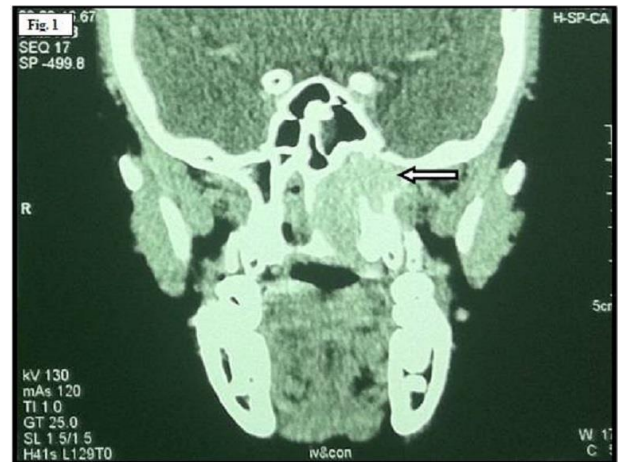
Computed tomography (contrast study) showing a well defined enhancing mass in the posterior nasal cavity and nasopharynx with extension to the left pterygopalatine fossa expanding and eroding the ipsilateral pterygoid process.
